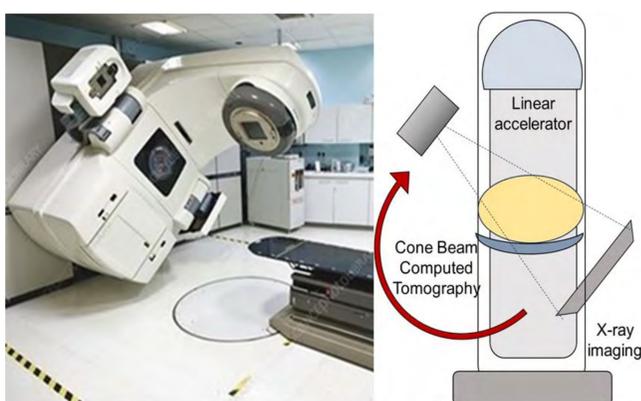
Cone beam CT imaging system on a linear accelerator
